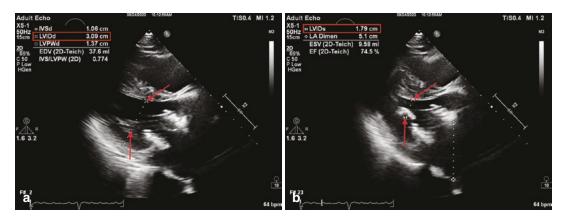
Parasternal long-axis view of a hyperdynamic ventricle during diastole (a) and systole (b), showing a small LVIDd (*red arrows*), suggesting low preload (hypovolemia)
